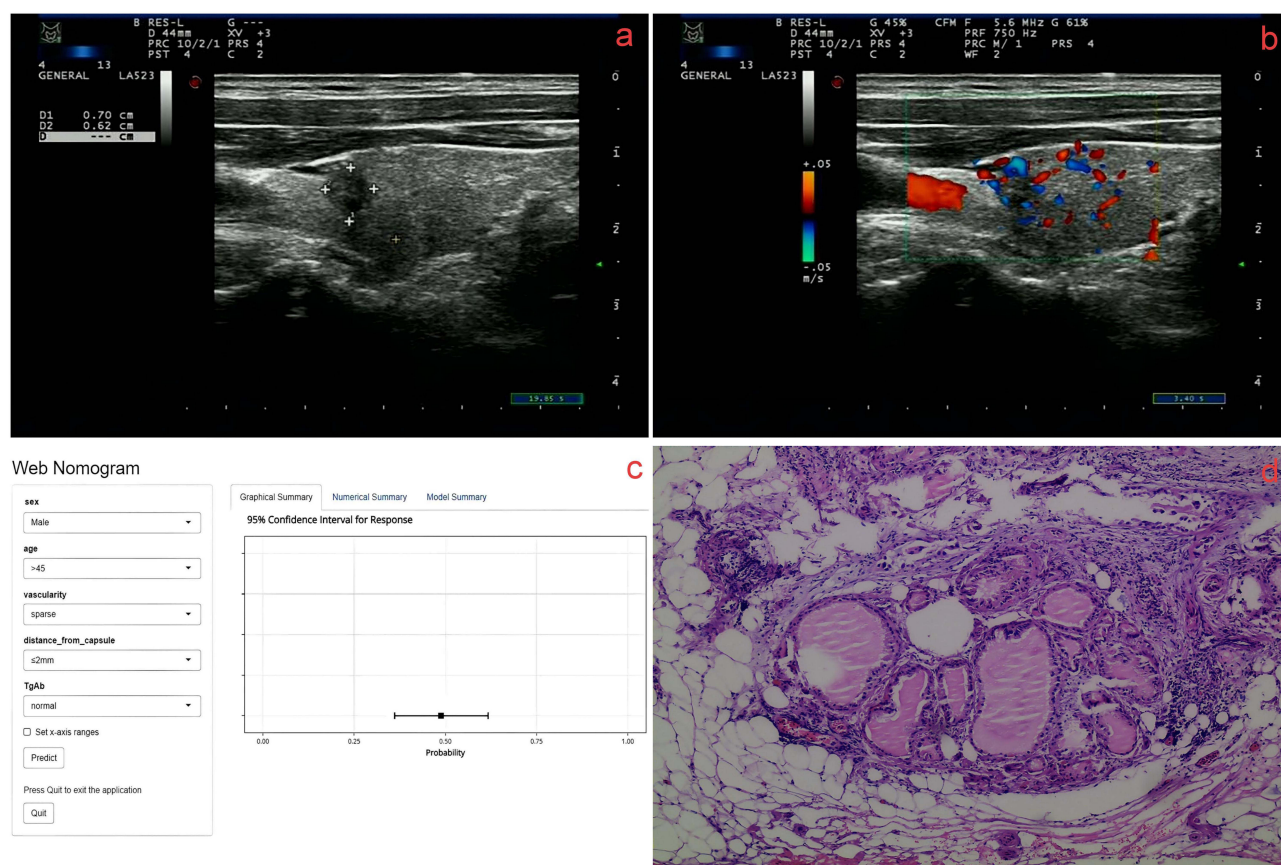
Dynamic nomogram prediction example for an indeterminate thyroid nodule. (a) Ultrasound image showing the thyroid nodule (0.70 cm × 0.62 cm) located ≤ 2mm from the capsule. (b) Ultrasound image indicating abundant vascularity in the thyroid nodule. (c) The web-based dynamic nomogram predicts a risk score of 0.838 for invasive PTC in this patient. (d) Pathological findings confirm the nodule as PTC, with cancerous tissue invading vascular walls and surrounding thyroid soft tissue.
